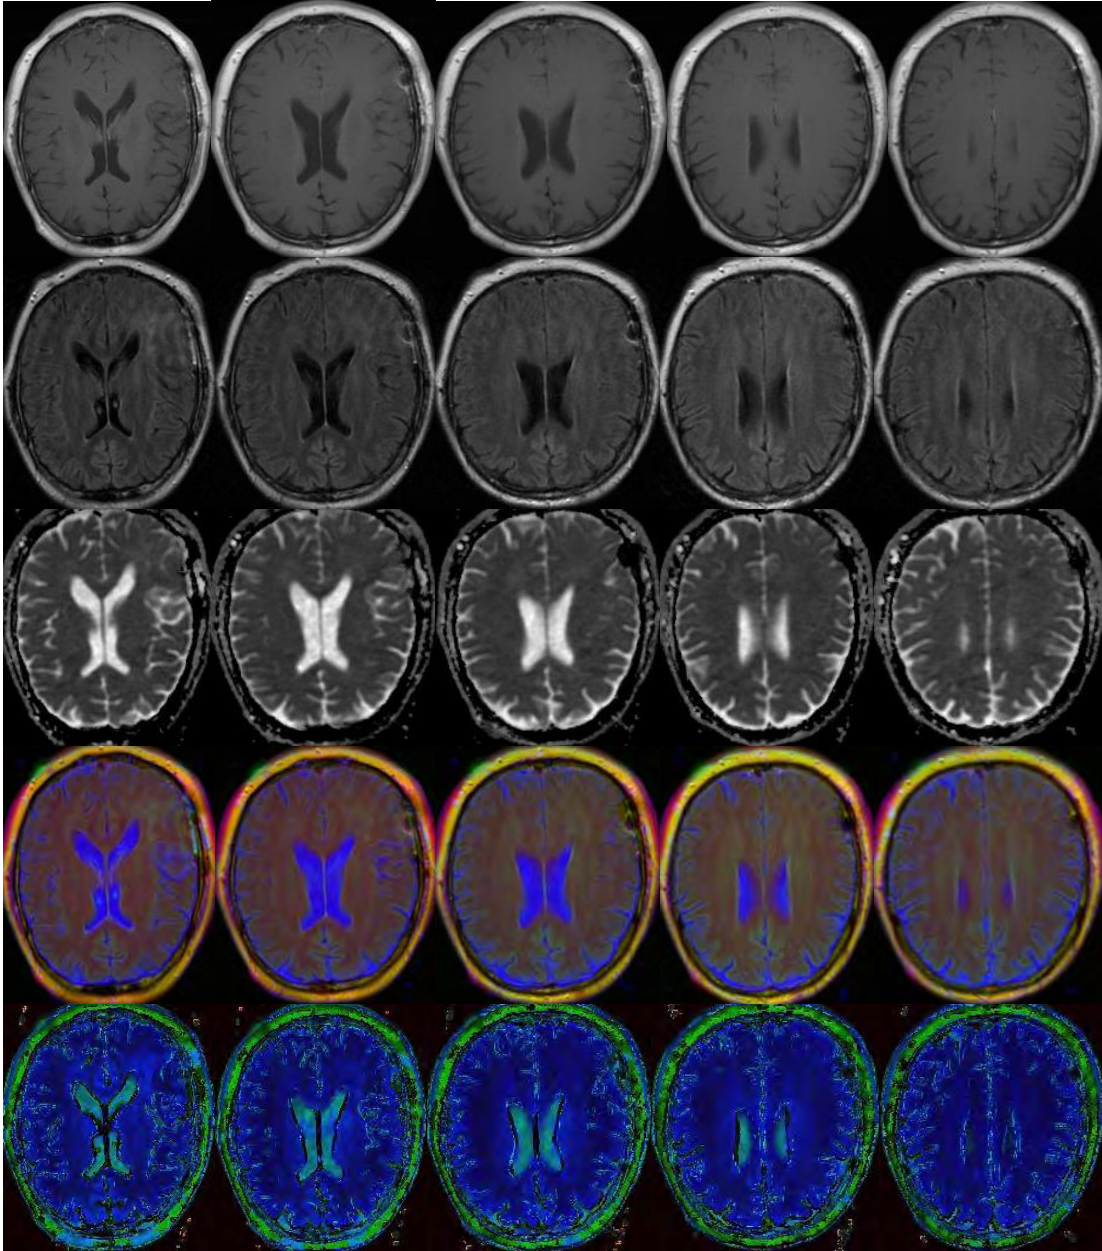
Original T1W, T2-FLAIR, and ADC images (row 1 to 3), combined color image (row 4), and generated signature map (row 5).
